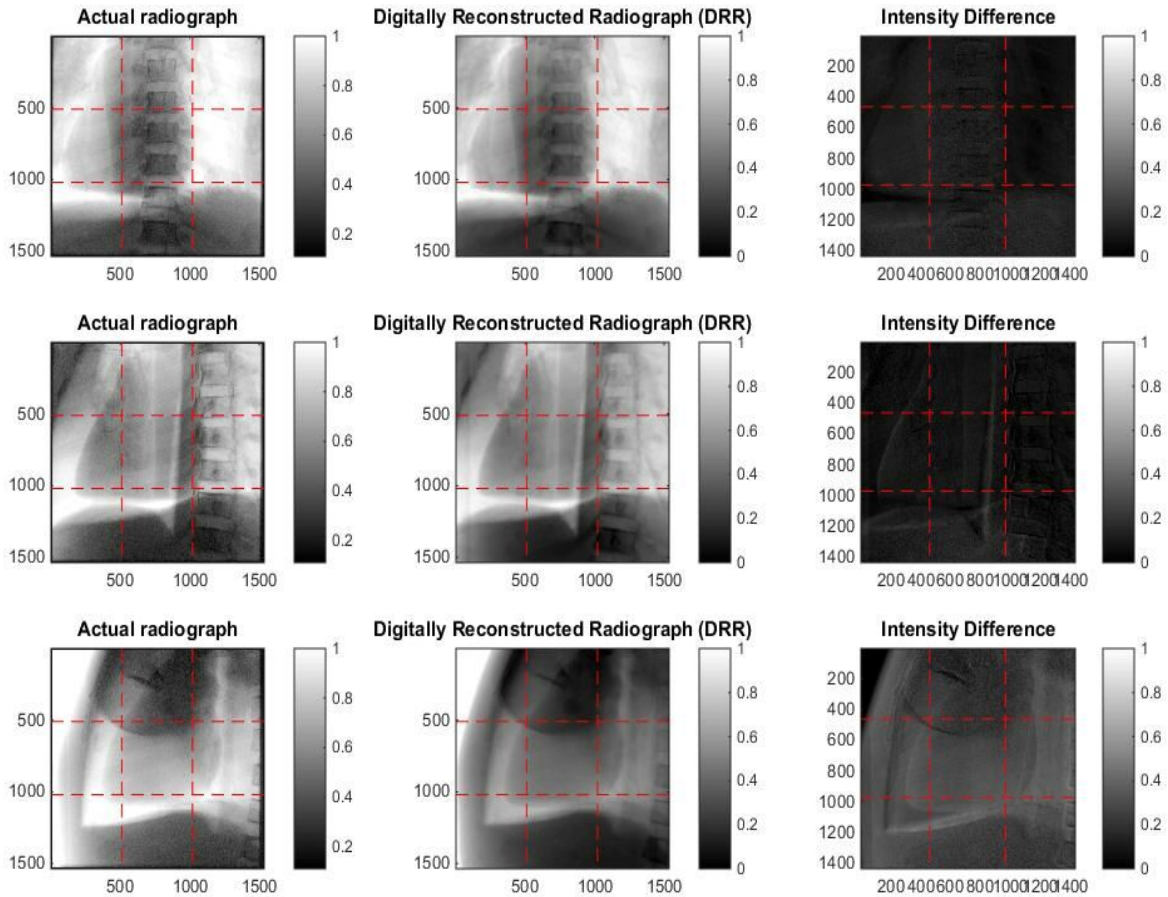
Comparison between real radiograph (left), DRR (middle), and normalized intensity difference (right)
